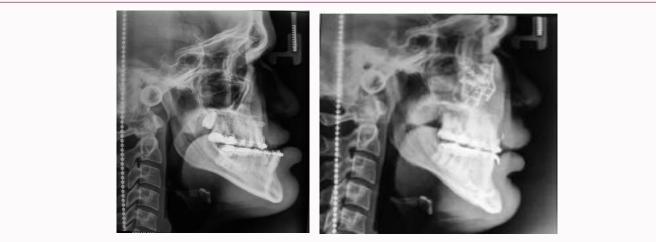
Pre- and post-surgery imagenologic radiographic and CT Scan control.
